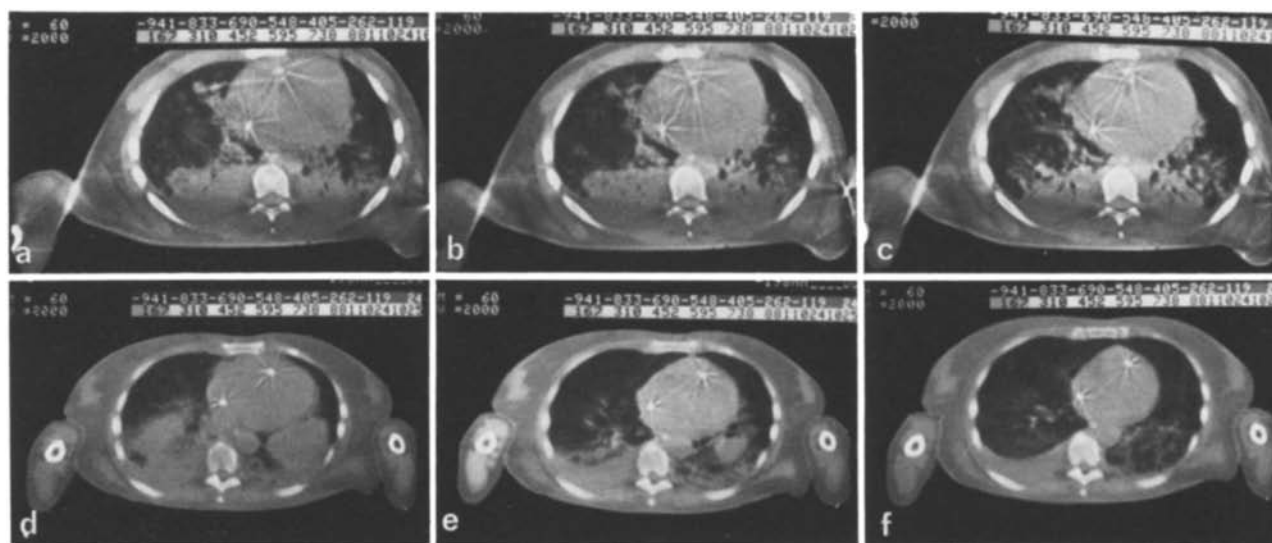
a – c ARF from bacterial pneumonia (pt 1). CT scan of the base at 5, 10 and 15 cm H₂O PEEP. No changes in density and PaO₂ are observed: a PaO₂: 97 mm Hg, density 59%; b PaO₂: 103 mm Hg, density 56%; c PaO₂: 106 mm Hg, density 53%. d – f ARF from sepsis (pt 10). CT scan of the base at 5, 10 and 15 cm H₂O. Substantial clearing of the densities is accompanied by increase of PaO₂. d PaO₂: 34 mm Hg, density 70%; e PaO₂: 49 mm Hg, density 52%; f PaO₂: 121 mm Hg, density 32%
